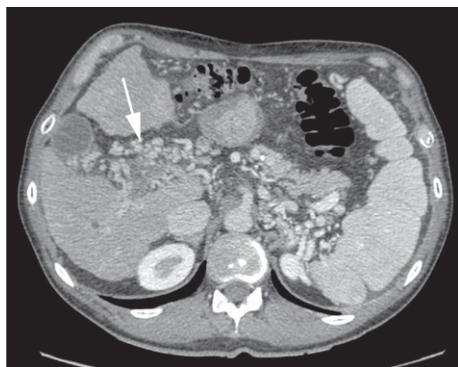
Helical computed tomography showing organized portal vein thrombosis with cavernoma (white arrow) in a cirrhotic patient at evaluation. The trunk of the portal vein which is no longer visible is surrounded by numerous collateral vessels.
